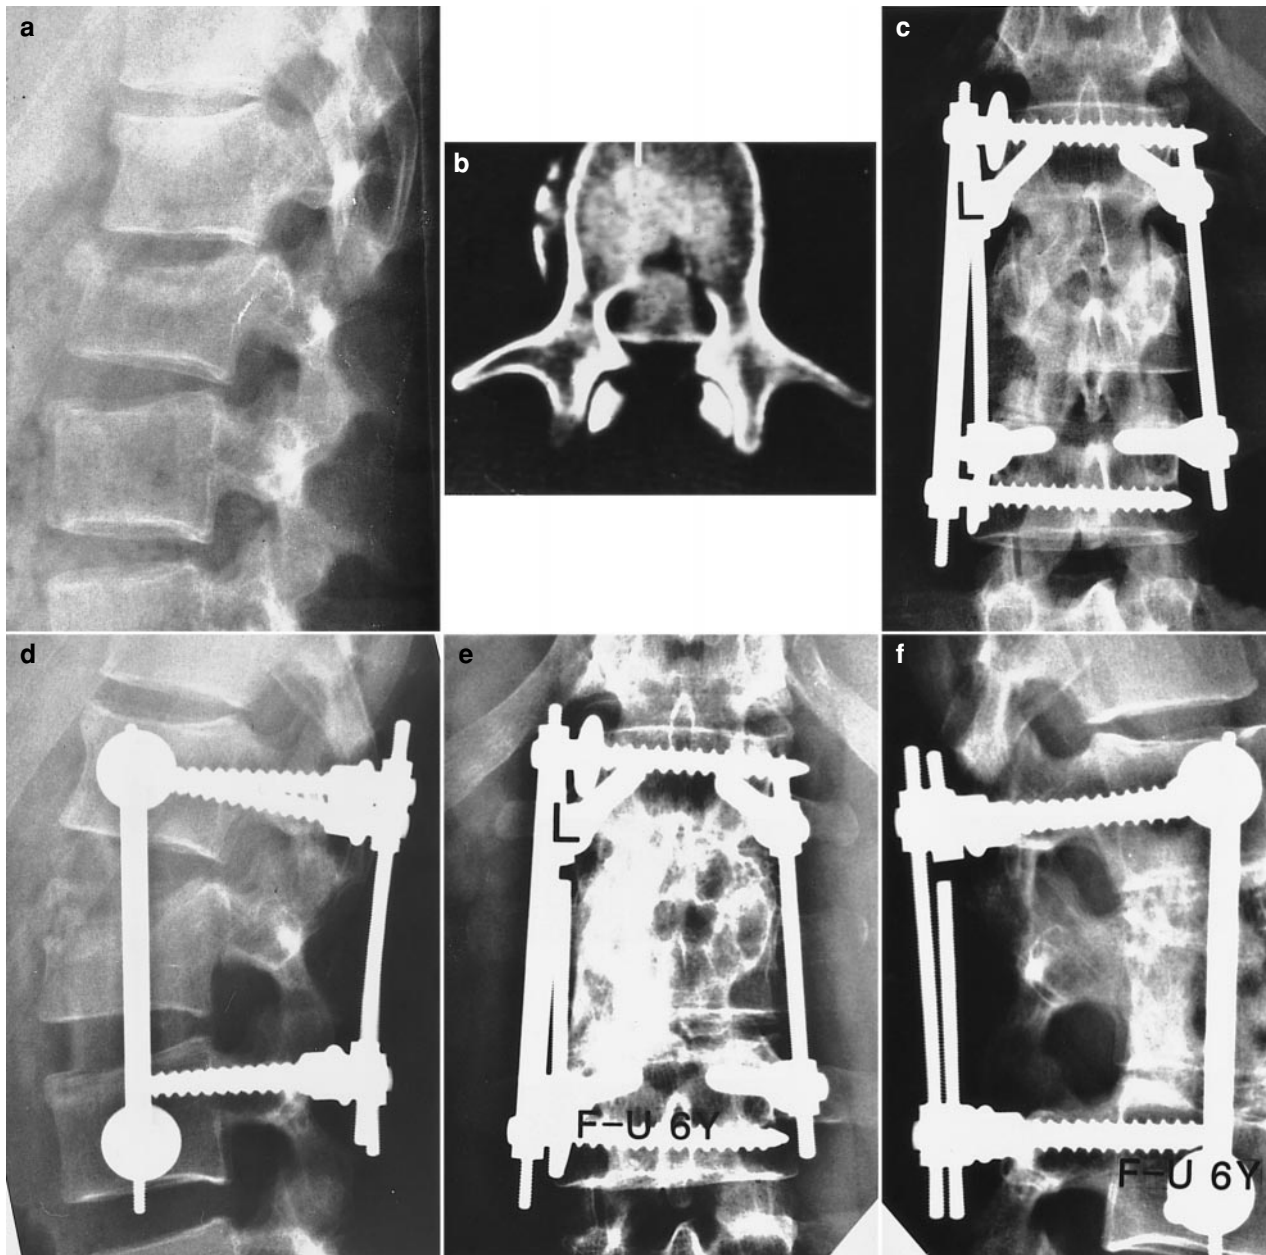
(a) Lateral radiograph of a burst-fracture L2. (b) Pre-operative CT-scan showing severe canal encroachment. (c, d) Immediate post-operative antero-posterior and lateral radiographs showing anatomical reduction after anterior decompression, anterior and posterior stabilisation. (e, f) Antero-posterior and lateral radiographs 6 years after surgery showing solid fusion with minor loss of reduction, despite posterior rod breakage
